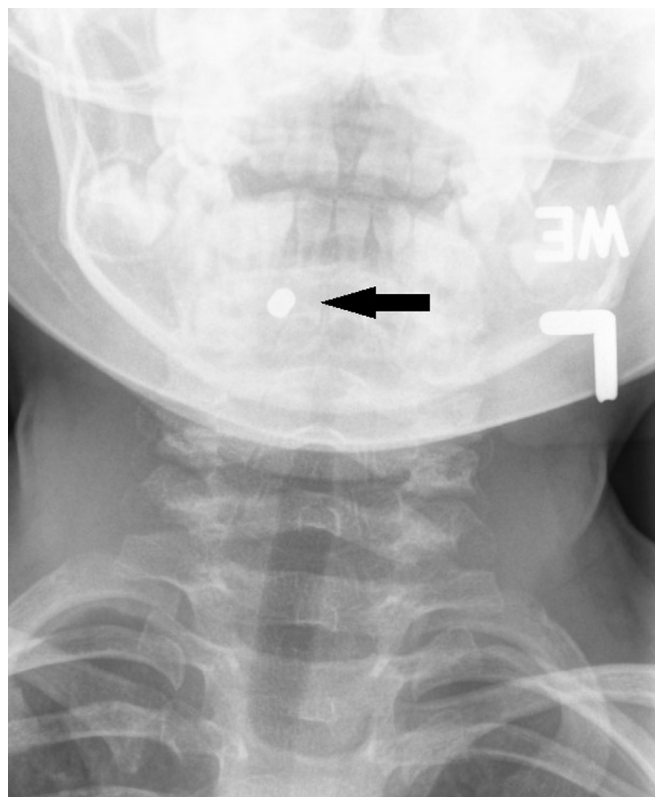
Anterior neck radiograph demonstrating 2 round radiopaque objects in region of vallecular (arrow).
